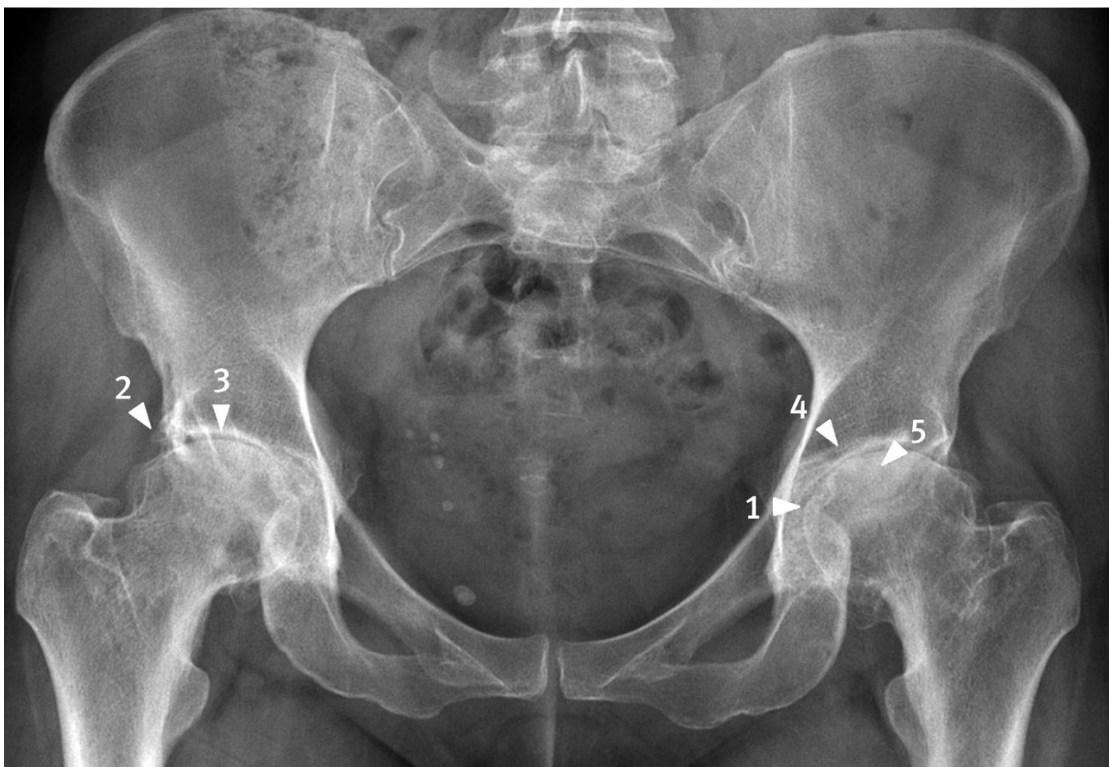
Typical plain radiograph of bilateral hip osteoarthritis. Notice the loss of joint space (1), osteophytes (2), subchondral sclerosis (3), and subchondral cysts (4). In this advanced case, there is also evidence of deformity of the femoral head (5). Joint space narrowing is the best diagnostic criterion (Croft et al., 1990). Figure adapted from (Aresti et al., 2016)
